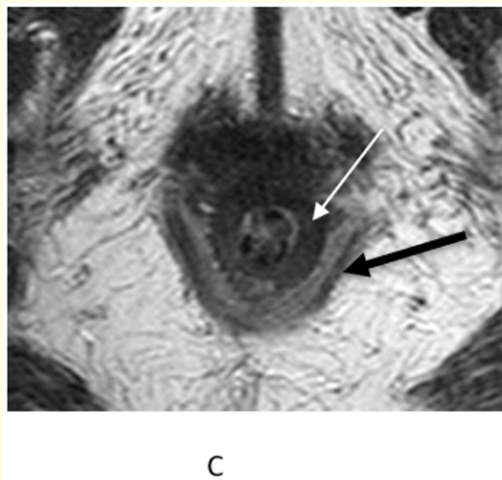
(A) Midsagittal MR image at rest in a 62 year old woman with fecal incontinence showing the loss of contrast through the anal gaping (white arrow) at the end of rectal filling; (B) Axial T2 w TSE MR image of the same patient showing the normal feature of the internal anal sphincter (thin white arrow) as opposed to the increased signal intensity consistent with atrophy of the external anal sphincter (black arrow) and that of (C) The puborectalis muscle (black arrow). Bl = Bladder; V = Vaginal canal outlined by contrast; R = Rectal ampulla.
